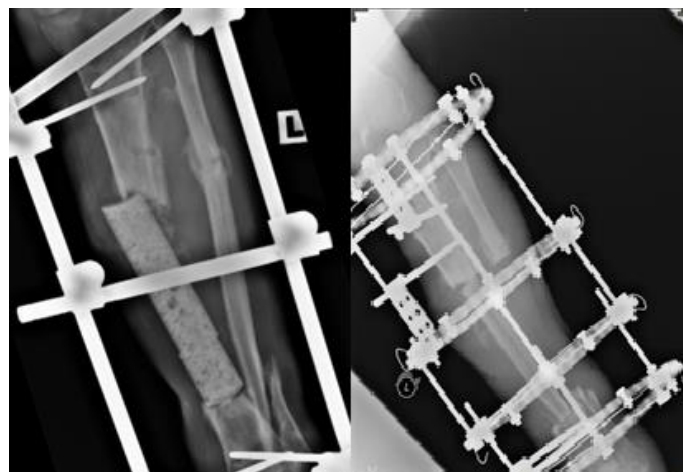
Plain radiograph of left tibia pre and post tibialization of fibula
